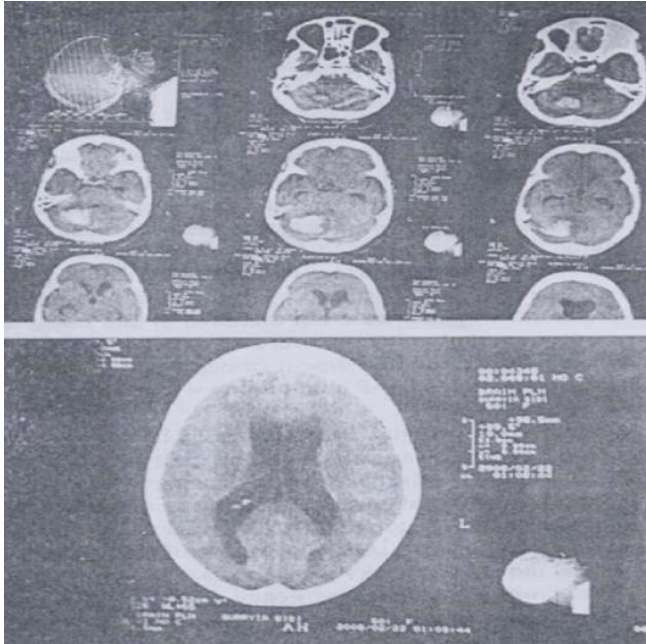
a: Preoperative CT Scan brain showing cerebellar haematoma with obstructive hydrocephalus.
